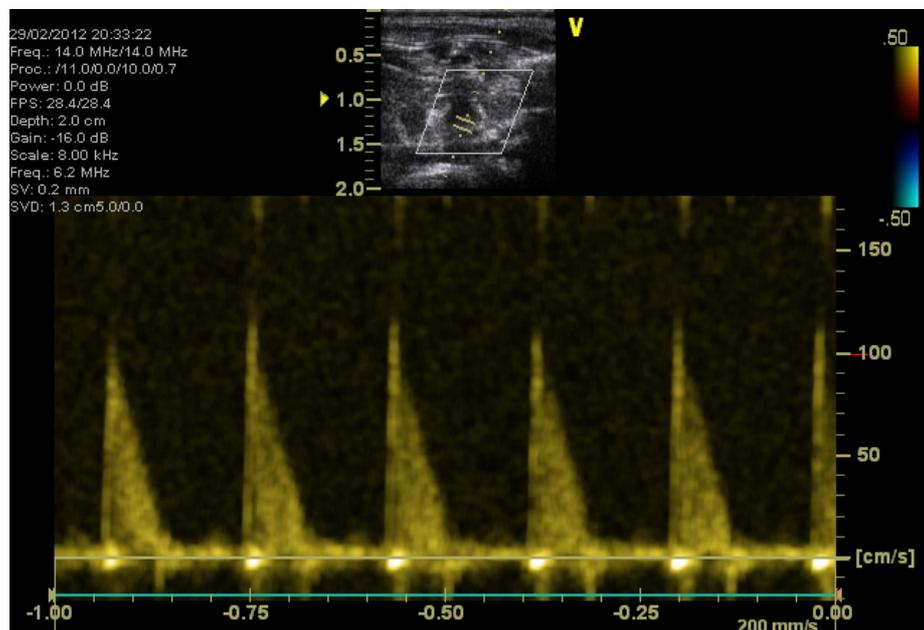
Blood flow measurements in the aortic arch. Colour Doppler was used to ensure correct probe placement. The waveform displays velocity (y-axis) over time (x-axis). The area under each waveform (velocity-time integral; VTI) is proportional to stroke volume.
